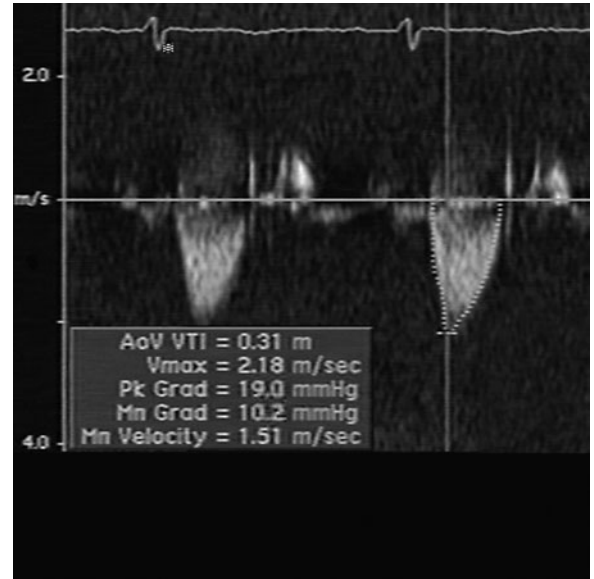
Continuous wave Doppler velocity envelope of full root Freestyle valve.
